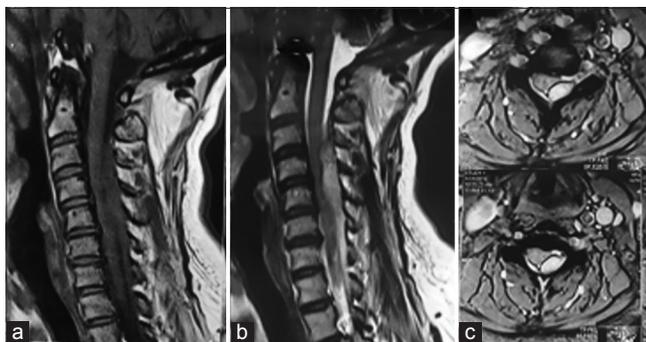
Preoperative cervical magnetic resonance imaging: (a) T1-weighted sagittal shows an isointense mass compressing the cord, (b) in T2 weighted, the mass is hyperintense compatible with acute hematoma, (c) The mass is biconvex in T2-weighted axial view compatible with epidural hematoma.
